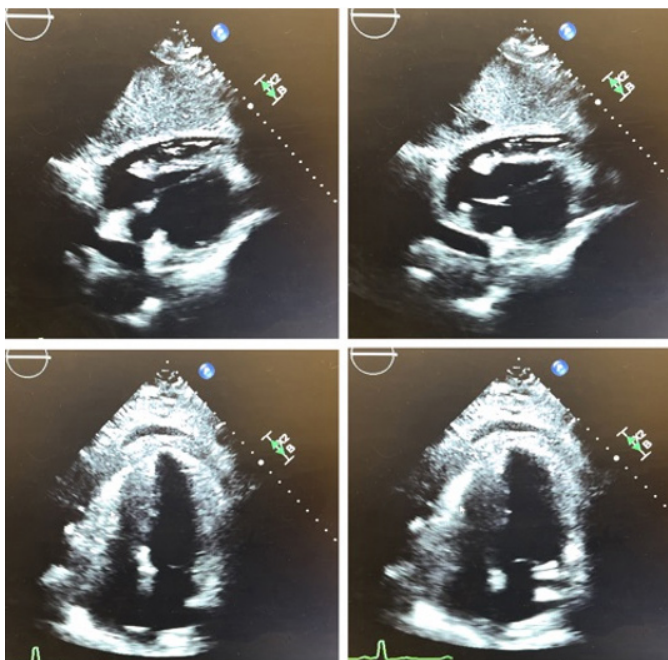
Final echo prior to discharge showing pericardial thrombus. Top images: Subxiphoid view; Bottom images: Apical 4-chamber view.
